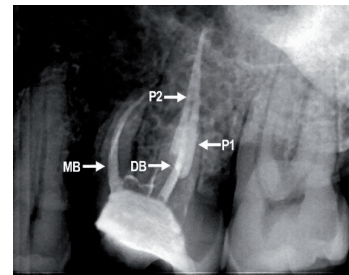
Obturation radiographs.
